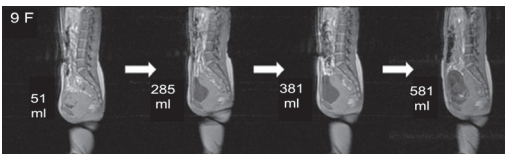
Different shapes of full bladder and bladder filling in one of the ten subjects in the MRI experiment; bladders are mainly filled in an upward direction; the shape of a full bladder differs but the bladder bottom remains in place; subject exercised chest respiration to avoid artifacts of the abdominal region in MRI recording
